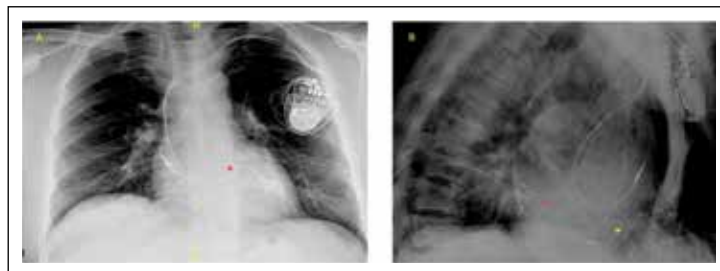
The images show lead positions in a patient with LOT CRT-P in frontal (A) and lateral chest radiographs (B). Note that the thinner 3830 Medtronic lead is positioned in the basal RV septum (yellow*) and LV lead (red*). The RA lead in the lateral film shows an "U" configuration, which indicates an adequate loop in the lateral film. The reader can compare with Figure 14 to get a visual impression of the optimal atrial lead loop.
